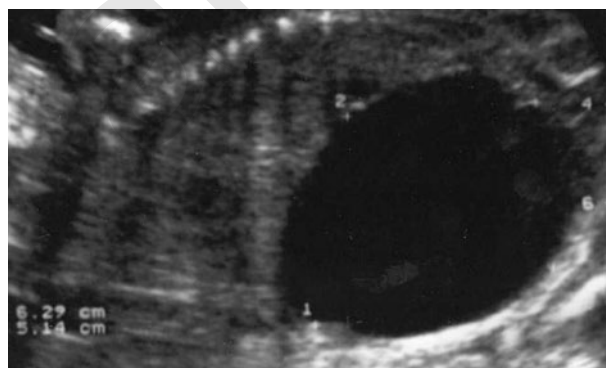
Massive enlarged fetal bladder: longitudinal view of abdominal ultrasound at 22 weeks' gestation, fetus in prone position.
